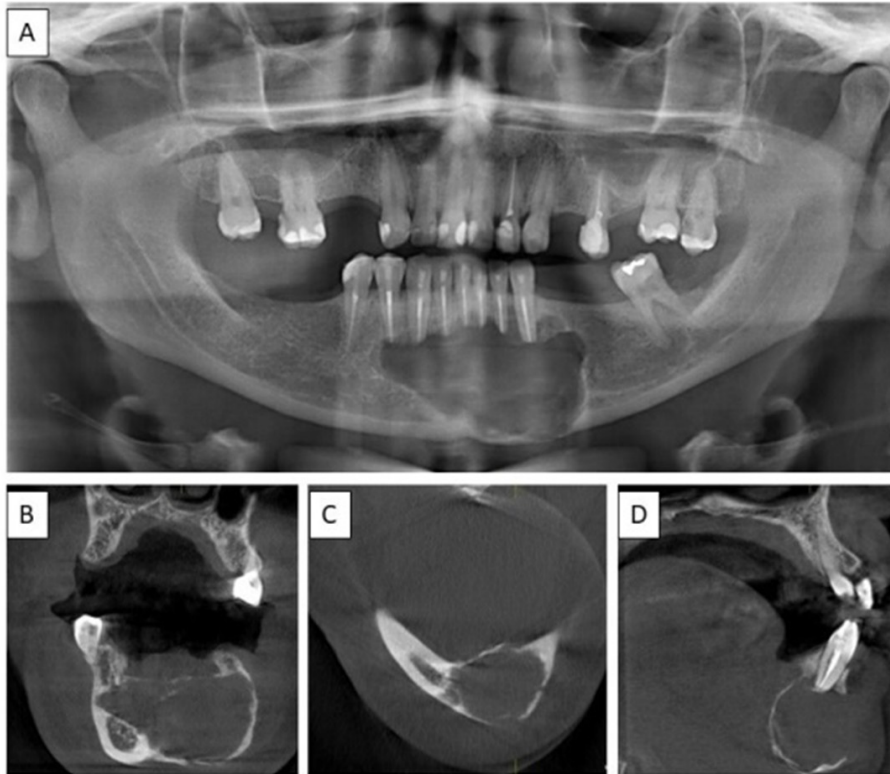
A) Immediate postoperative panoramic radiograph showing removal of the lesion and apicoectomies of teeth 33-44, with a small volume of remaining bone; immediate postoperative cone beam CT: B) Coronal section; C) Axial section; D) Sagittal section, showing lesion removal, apicoectomies of teeth 33-44, and thin cortical bone.
